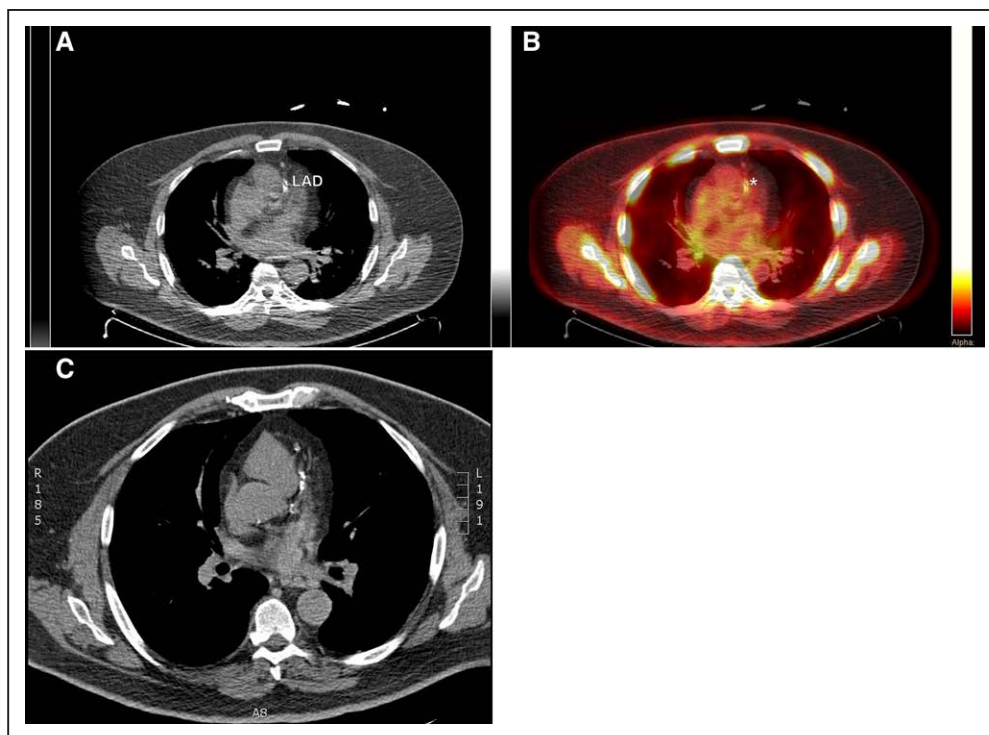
Low-resolution attenuation computed tomographic scan of the chest showing calcification in the mid-left anterior descending coronary artery (A). Fused positron emission tomography/computed tomography images showing uptake of ^{18}F -sodium fluoride (identified by the asterisk) in the mid section of the left anterior descending (LAD) coronary artery matching the calcified plaque seen on the attenuation chest computed tomographic scan (B). The high-resolution gated chest computed tomographic scan confirms the presence of several areas of calcification along the course of the LAD coronary artery (C).
